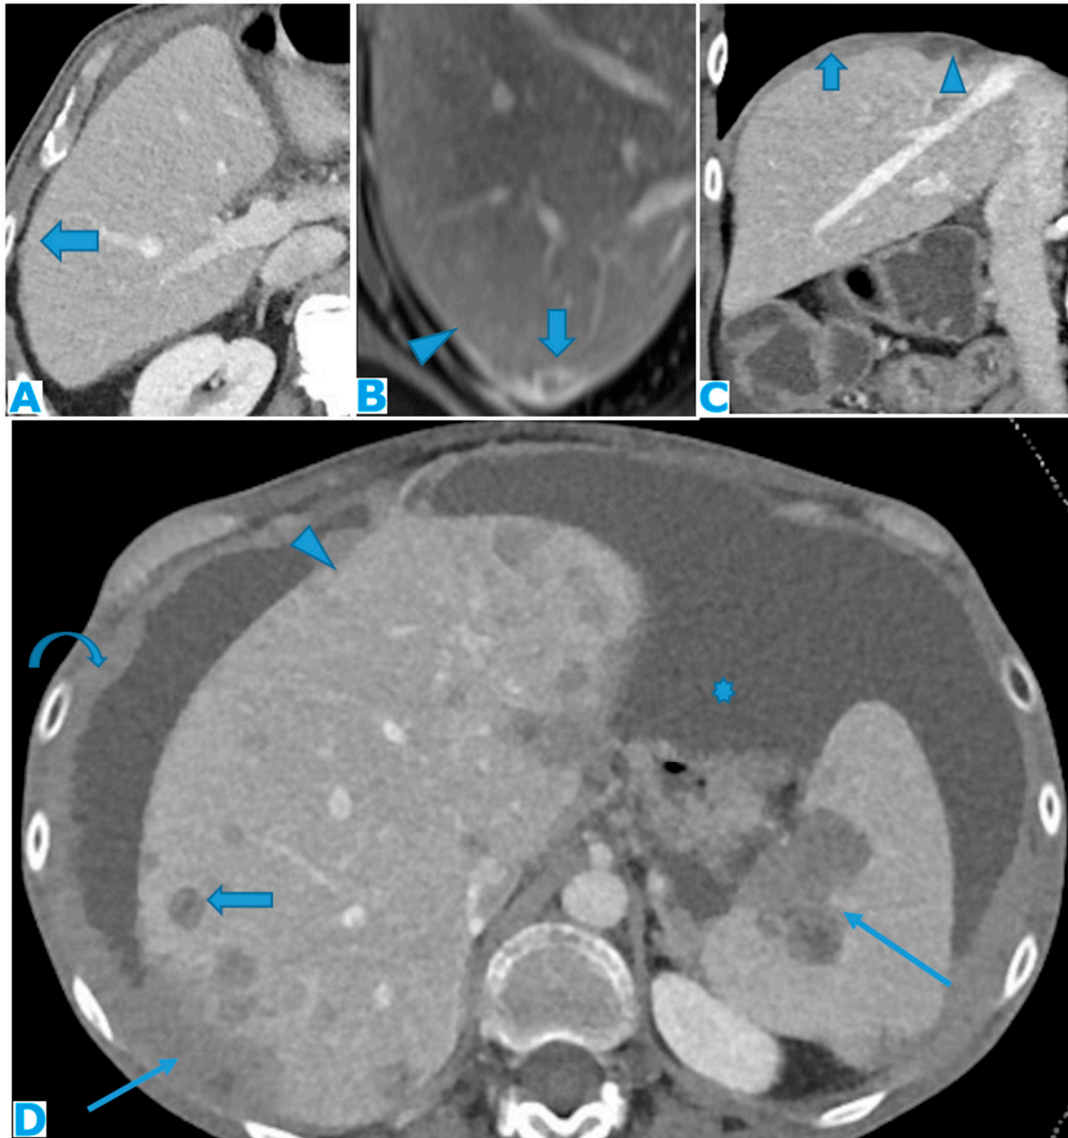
Axial CE-CT (A): PC from colon carcinoma: Note the subtle irregularities of the liver contour caused by the deposit seeding within the peritoneum covering the hepatic surface. CE portal phase FST1WI (B): PC from cervical carcinoma: Notice the difference between the linear subcapsular deposits (arrowhead) and the biconvex subcapsular deposit with parenchymal invasion (arrow): observe the scalloped appearance of the underlying parenchyma. CE-CT coronal MPR (C): PC from colon carcinoma: Thickening of the right diaphragm caused by deposit seeding (arrow). Notice the difference with the subcapsular deposits that scallop the liver contour (arrowhead). Axial CE-CT (D): PC from ovarian carcinoma: Subcapsular deposits with parenchymal invasion (thin arrows), both hepatic and splenic. Observe how they differ from hepatic metastases, well defined and completely surrounded by parenchyma (arrow). Note also perihepatic (arrowhead) and right subphrenic deposits (curved arrow). Ascites (*).
